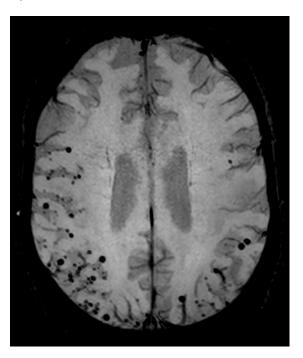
Cerebral microbleeds in A) patient with cerebral amyloid angiopathy as detected by susceptibility weighted imaging and B) patient with hypertensive angiopathy detected by T2*-gradient echo on magnetic resonance imaging (axial cut)
